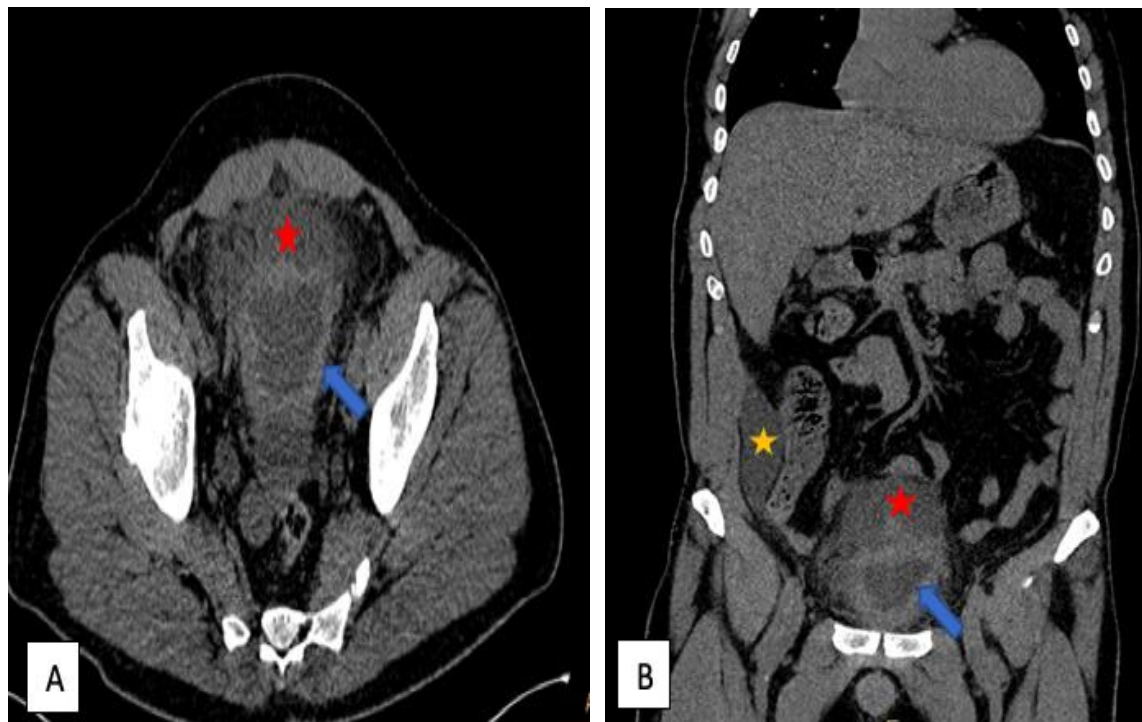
Non-contrast abdominal CT images: (A) in axial slice, and (B) in coronal slice showing perivesical ascites (red star), and at the level of the right paracolic gutter (yellow star).
